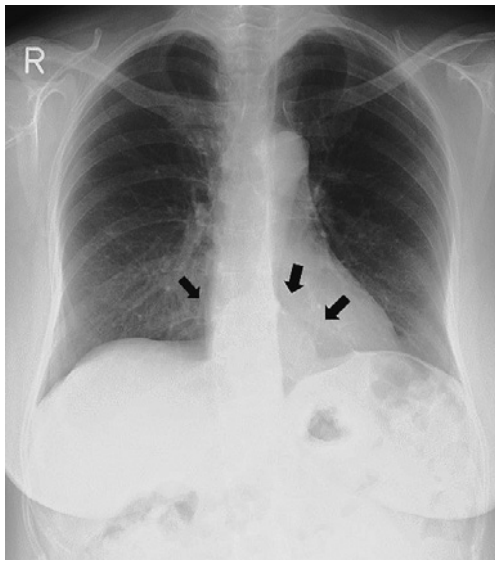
Chest X-ray revealed a retrocardiac mass (arrows).
